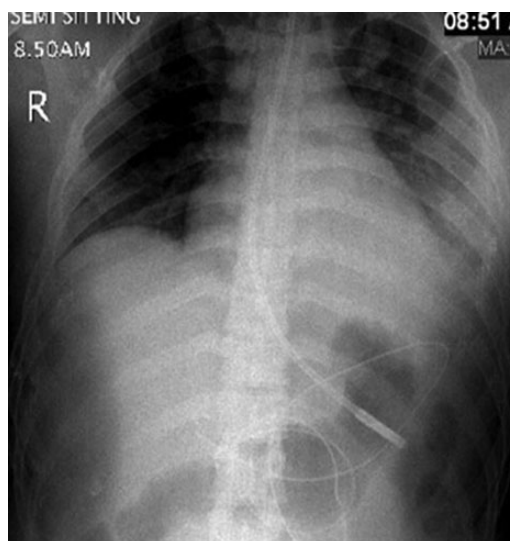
Chest X-ray demonstrated a large left-sided pleural effusion.
